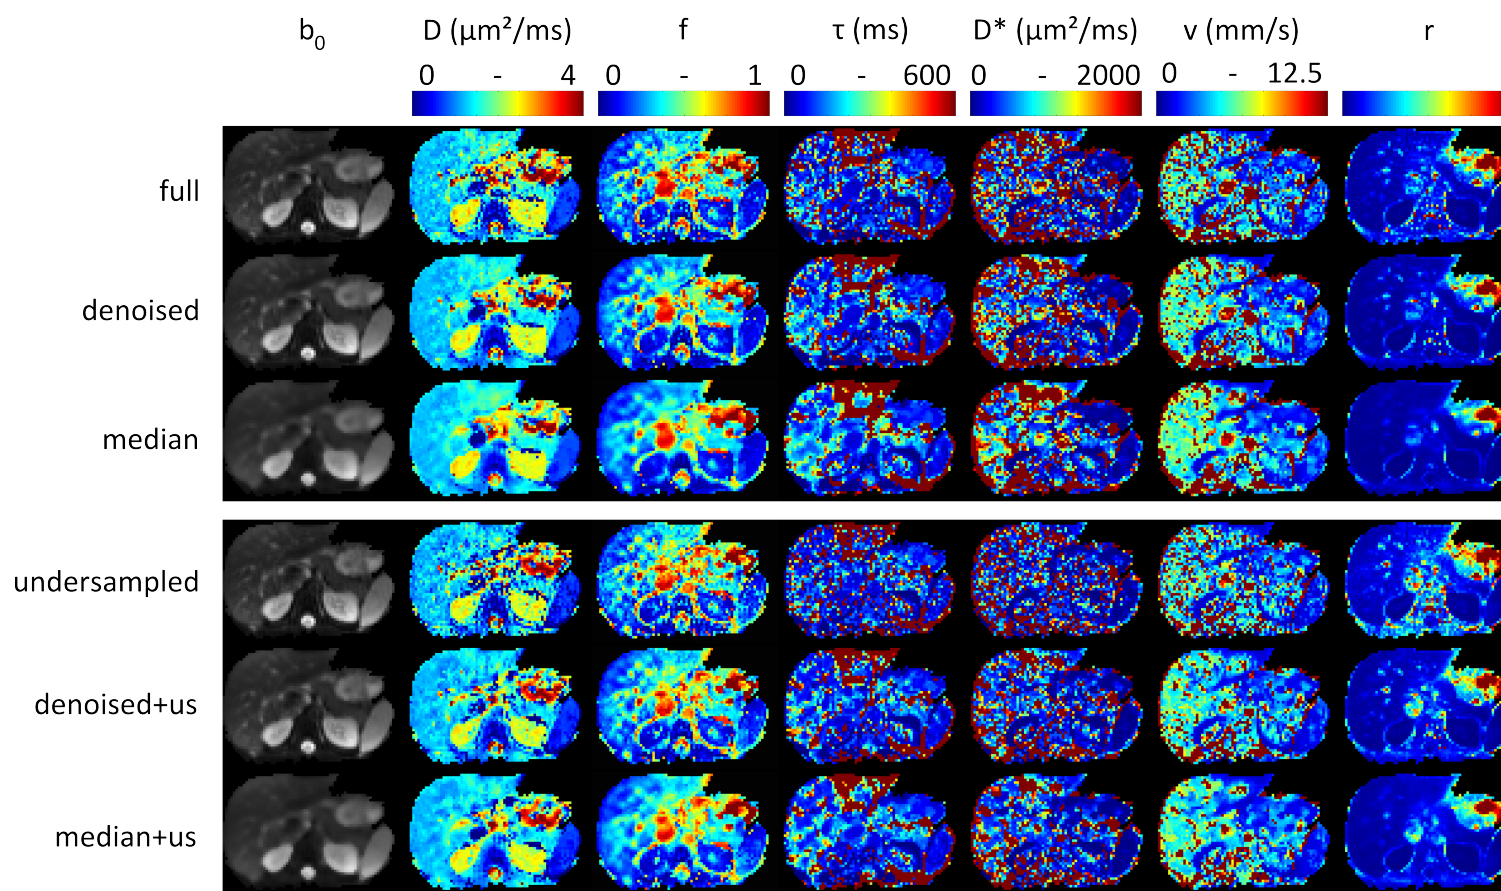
Similar conclusions to those made for Fig. 6.2 can be made for a second test subject. The red borders in the D^* -maps however indicate, that the test subject might have moved slightly during the duration of the MRI experiment. This might be the reason why the denoised (pixel-wise KLT) τ and D^* -maps in this case appear less affected, than the smoothed median maps.
